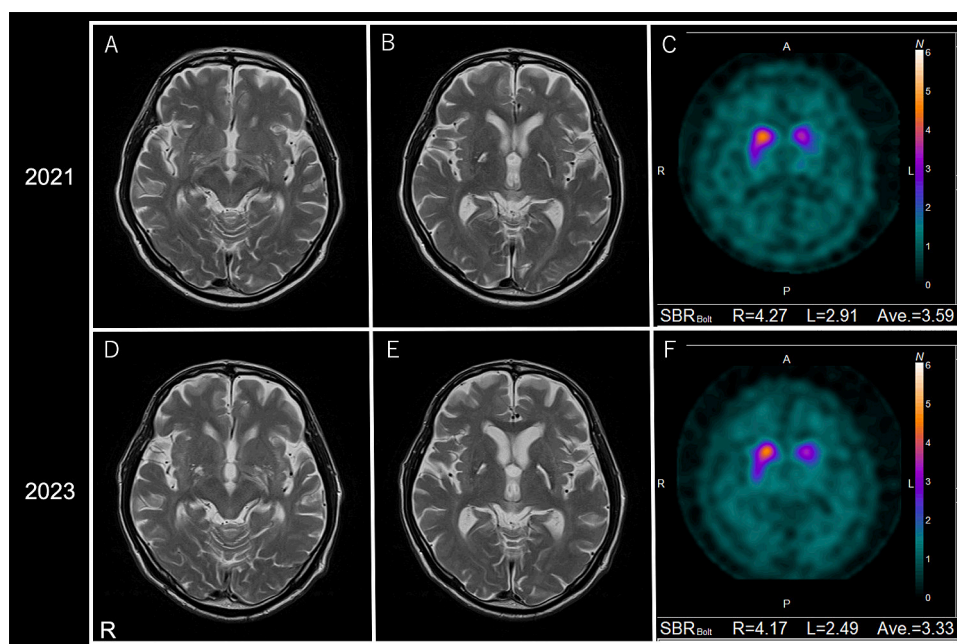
Brain MRI and DAT scan images.
